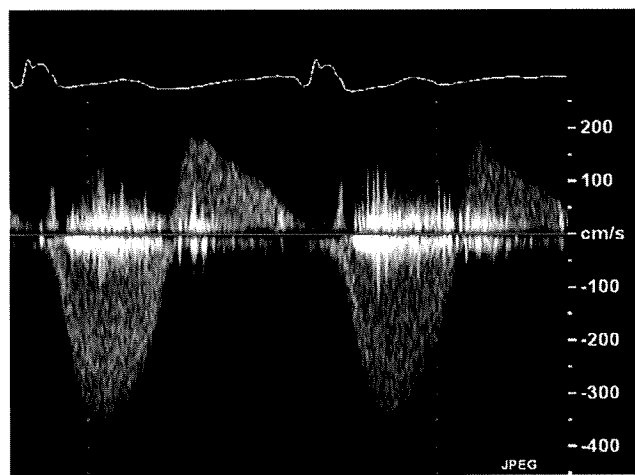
Two-dimensional echocardiographic evaluation of a RV-to-pulmonary artery homograft valve conduit after repair of a truncus arteriosus, interrogated from the left parasternal view. Forward flow (blue) and retrograde flow (red) of pulmonary regurgitation is seen. Pulsed Doppler shows aliasing signals of stenosis and a retrograde signal of regurgitation at the level of the valve. CW Doppler signal from the valve conduit shows significant stenosis and regurgitation.
